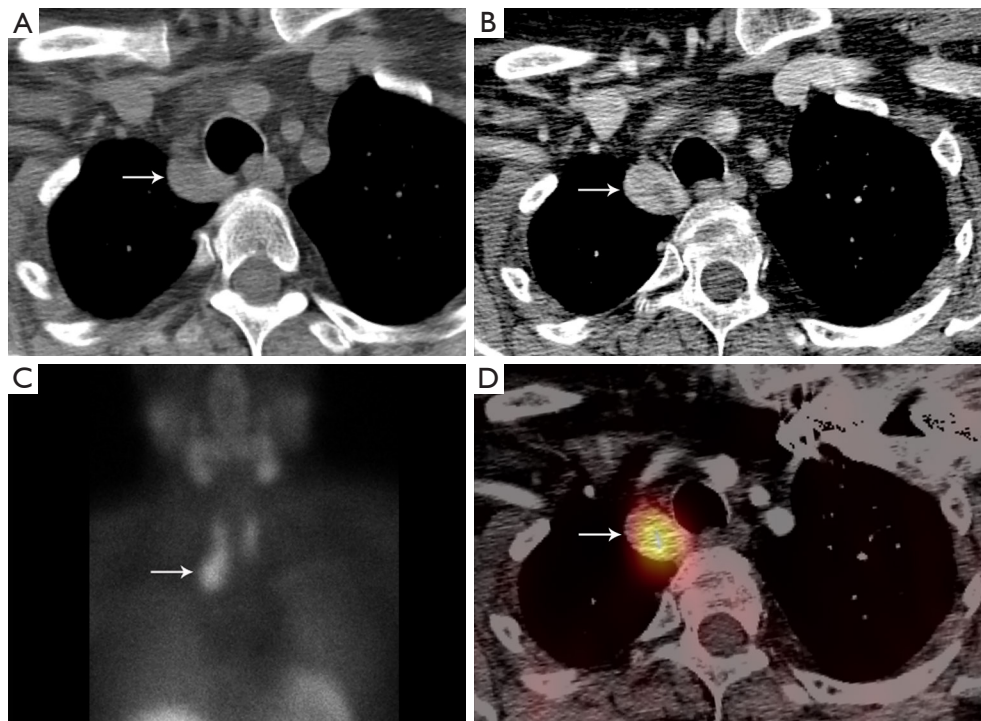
Ectopic parathyroid adenoma. (A,B) Pre- and post-contrast enhanced CT show right paratracheal solid lesion (arrow) with heterogeneous enhancement. The pre-contrast CT is useful to differentiate high attenuation thyroid tissue from low attenuation parathyroid tissue. (C,D) Technetium-99m sestamibi parathyroid scintigraphy and SPECT/CT show the right parathyroid adenoma is sestamibi avid (arrow). CT, computed tomography; SPECT, single photon emission computed tomography.
